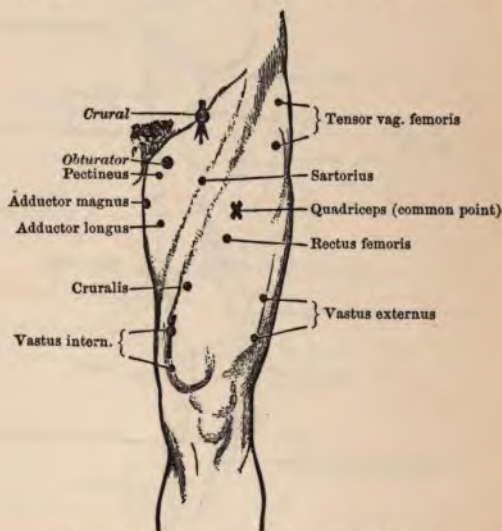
MOTOR POINTS OF ANTERIOR ASPECT OF LEFT THIGH.
